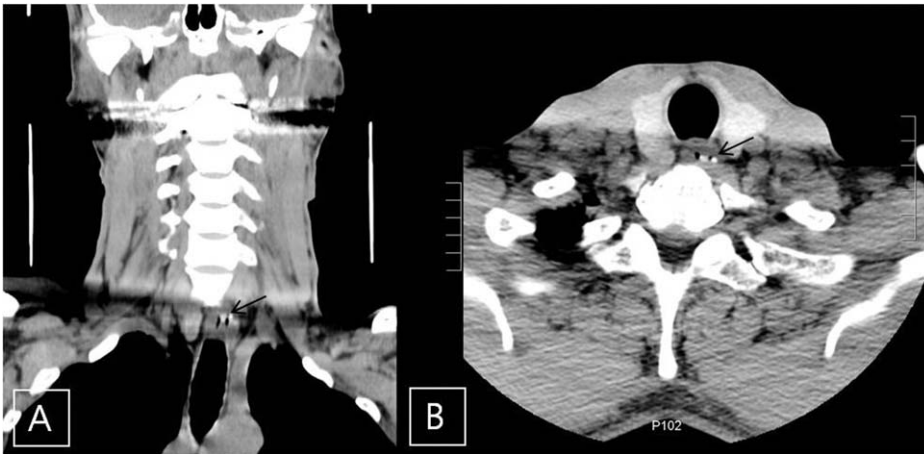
This is a false positive case, in which computed tomography showed a linear horizontal fish bone in the upper esophagus (black arrow). However, there was no fish bone on transnasal esophagoscopy examination.
